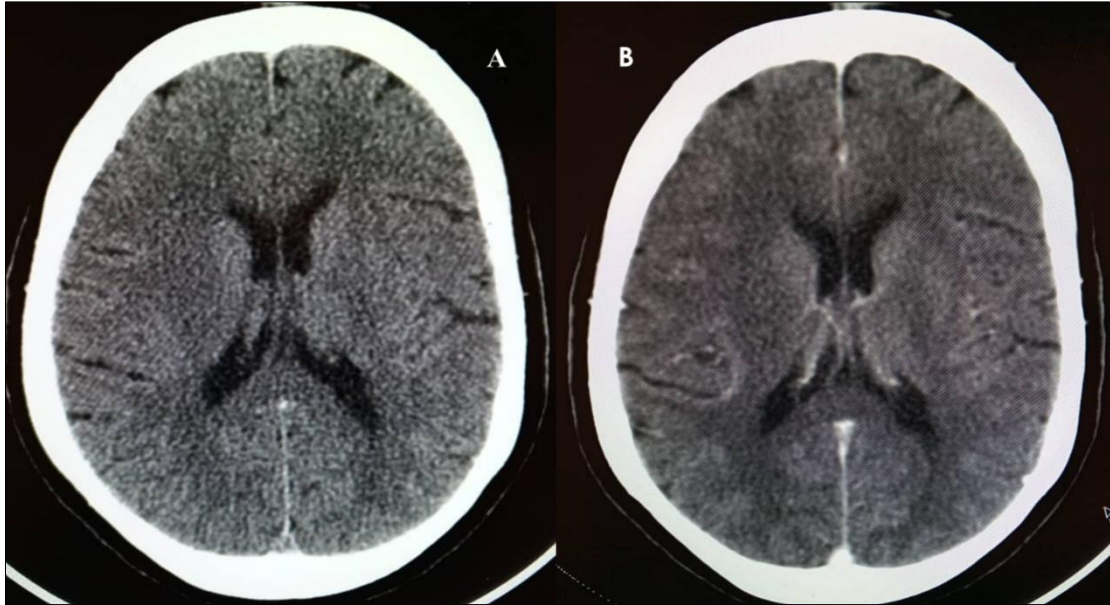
(A and B): normal brain CT scan
